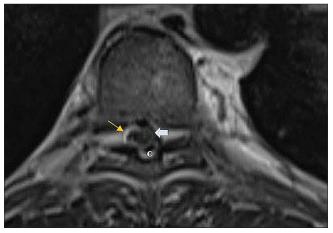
T2-weighted axial section shows the hypointense nodule (white broad arrow), compressing the cord © with surrounding hyperintense signal (yellow arrow) that corresponds to the cerebrospinal fluid cleft.
